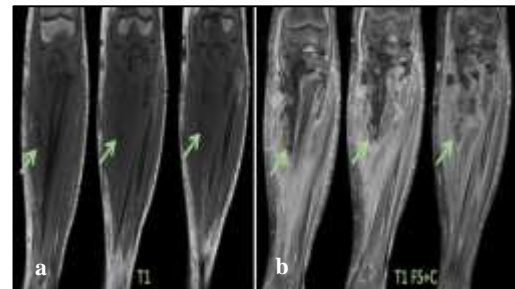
(a and b): 1 week follow-up MRI, interval worsening in proximal tibial destruction, with interval development of callus within the regional musculature representing myositis ossificans (green arrows).
